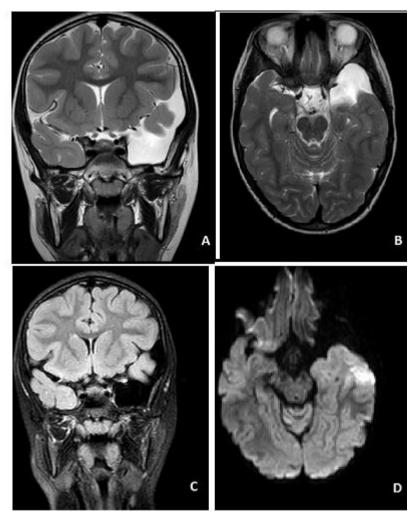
coronal (A) and axial (B) section MRI T2-weighted shows a well circumscribed extra-axial mass with the same high signal as CSF who became low intense in FLAIR-weighted image (C) without a restriction of diffusion (D)
